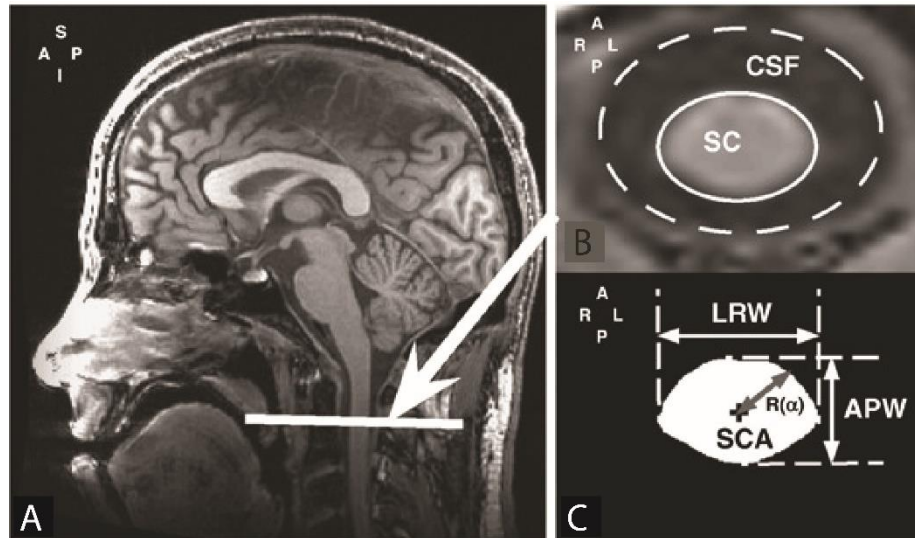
Examples of conventional T1-weighted (MPRAGE) in sagittal view in A and corresponding transverse section showing the spinal cord (SC) and surrounding cerebrospinal fluid (CSF) in B. The spinal cord morphometry is quantified in terms of spinal cord area (SCA), anterior-posterior width (APW) and left-right width (LRW) as shown in C. The figure is adapted from (Lundell et al. 2011).
